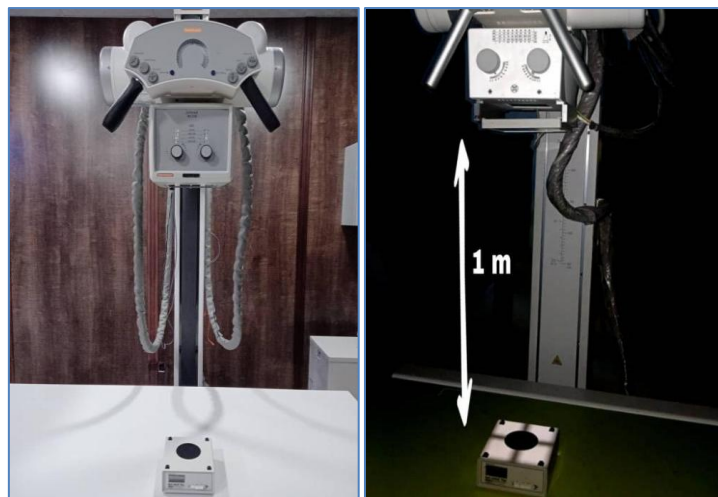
Measurement of output X-ray tube using aRad-Check Plus
